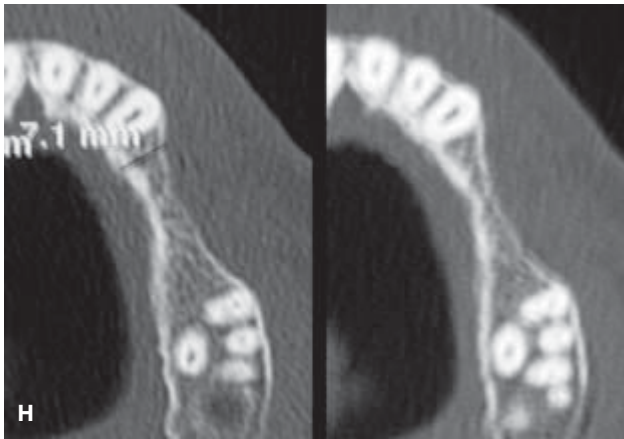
CT radiographic view showing a remarkable alveolar ridge deficiency.
